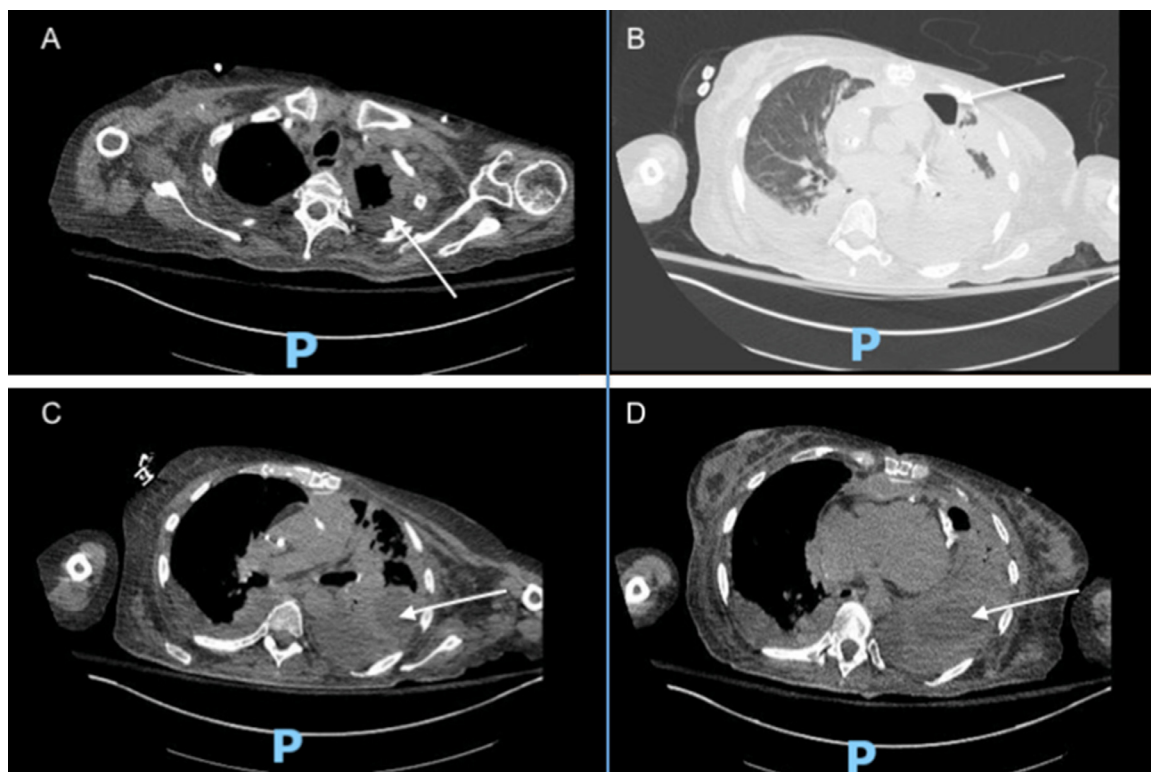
Computed tomography of the chest with axial cuts demonstrating a complex left pleural effusion with a component of hydropneumothorax. (A) Arrow demonstrating thickened left pleura. (B) Arrow demonstrating loculated pocket of air anteriorly with fluid posteriorly (hydropneumothorax). (C) Arrow demonstrating complex left pleural space with atelectatic lung, loculated pleural effusion, and thickened pleura. (D) Arrow demonstrating loculated pleural effusion.
